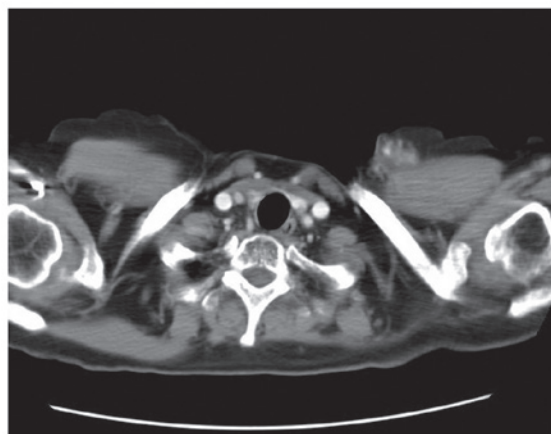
Chest computed tomography scan performed 18 years subsequent to radiation therapy for non-Hodgkin's lymphoma. A 2.5 cm diameter nodule anterior to the insertion of the left sternocleidomastoid muscle was identified.
